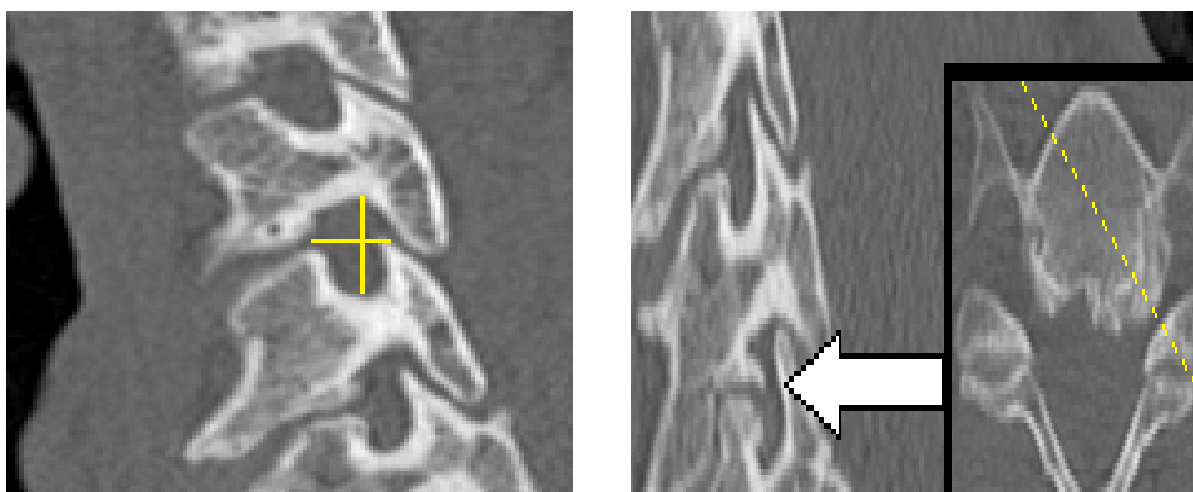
Measuring maximal height and transverse diameter of right C4-C5 foramen on Computed Tomography (CT) image
